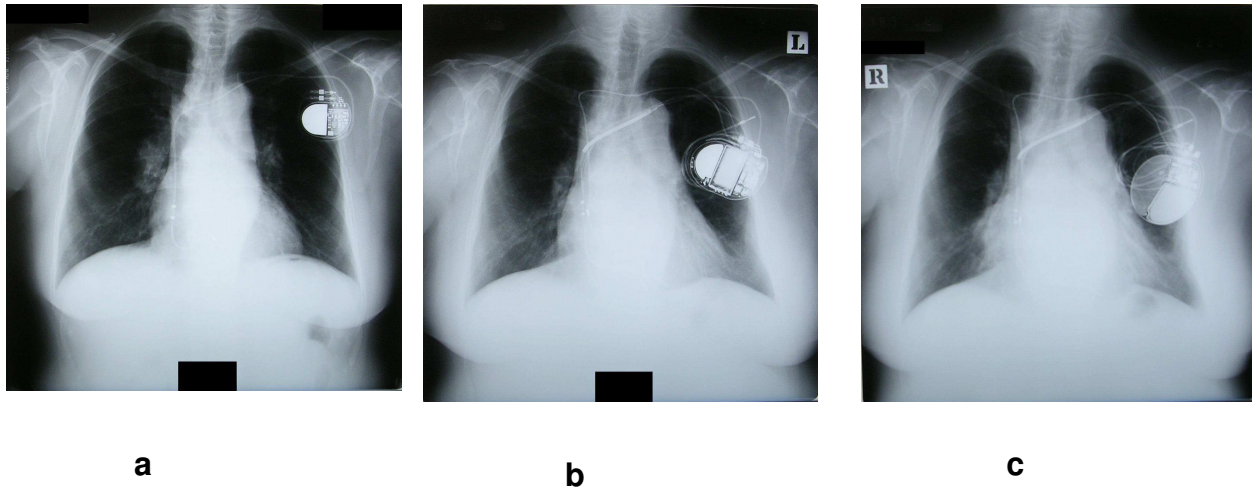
Longitudinal course of plain chest radiograph 74-year-old female, nonsmoker, eye, renal stone, BHL, ACE 28.3, heart with complete AV block a: when the corticosteroid therapy was introduced, b: after 5 years of treatment, c: after 7 years of treatment
